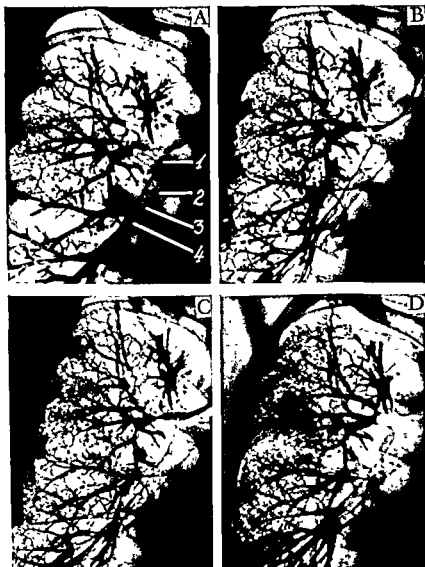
A, P, C, and D. S = segment of the complete branching of filling of the right lung. B = consolidation of the lower lobe. C = consolidation of the lower lobe. D = consolidation of the lower lobe by hydatid cyst removed. Roentgenographically only a residual tracing remains. Dynamics, however, is far from normal.
